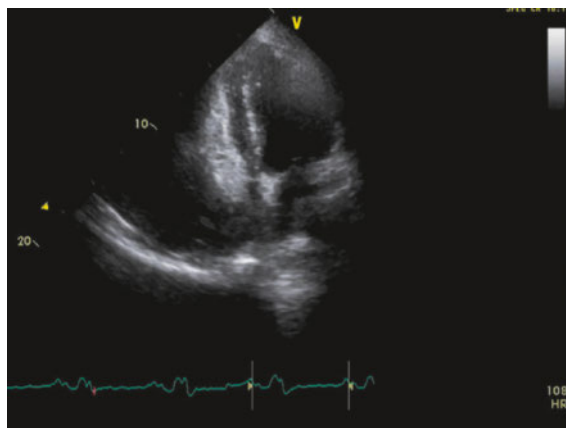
Apical four-chamber view in a patient with cardiac tamponade. There is pronounced compression of right atrium and right ventricle.
